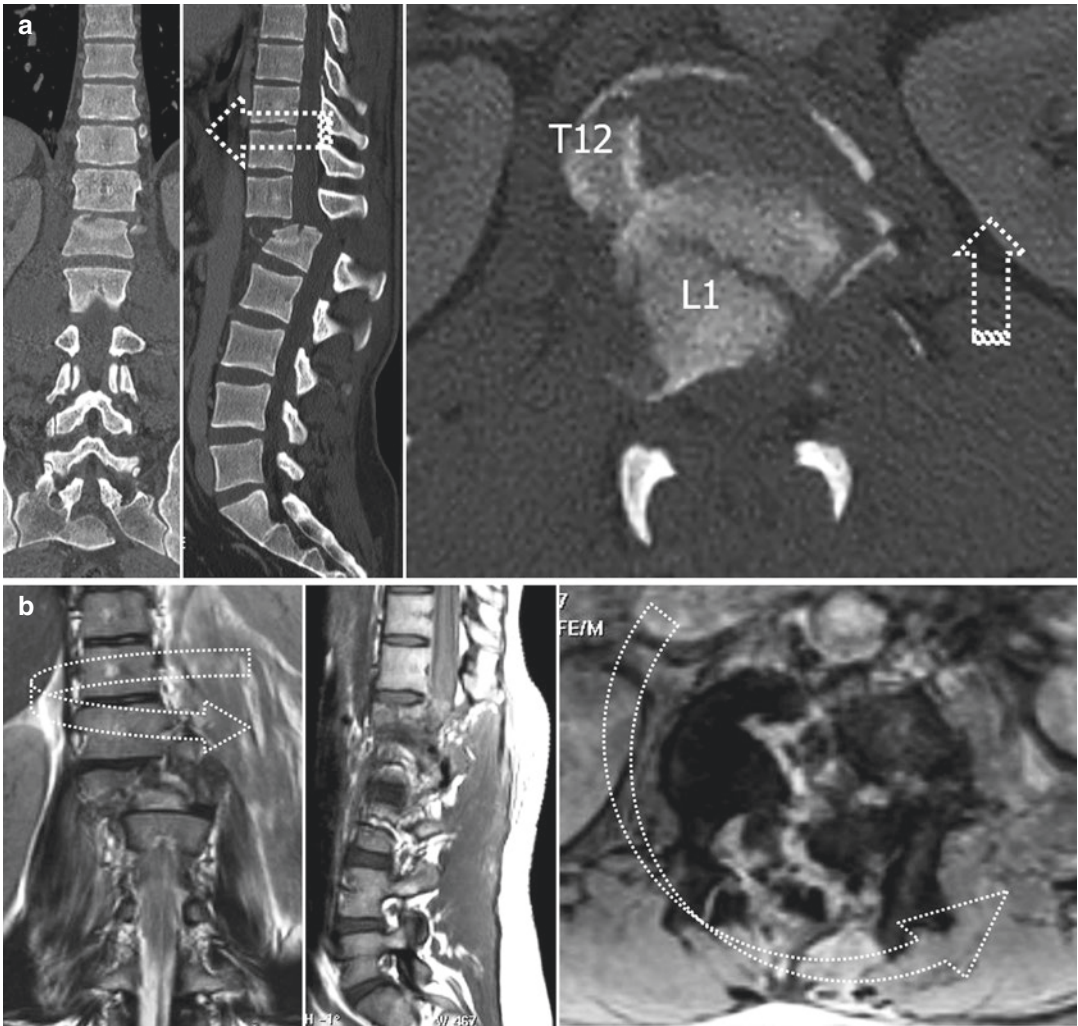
Translational (a) and rotational (b) injury mechanisms in two different patients with fractures of L1: 2D-reformatted coronal and sagittal, and source axial CT images (a), T1-weighted sagittal, T2-weighted coronal
